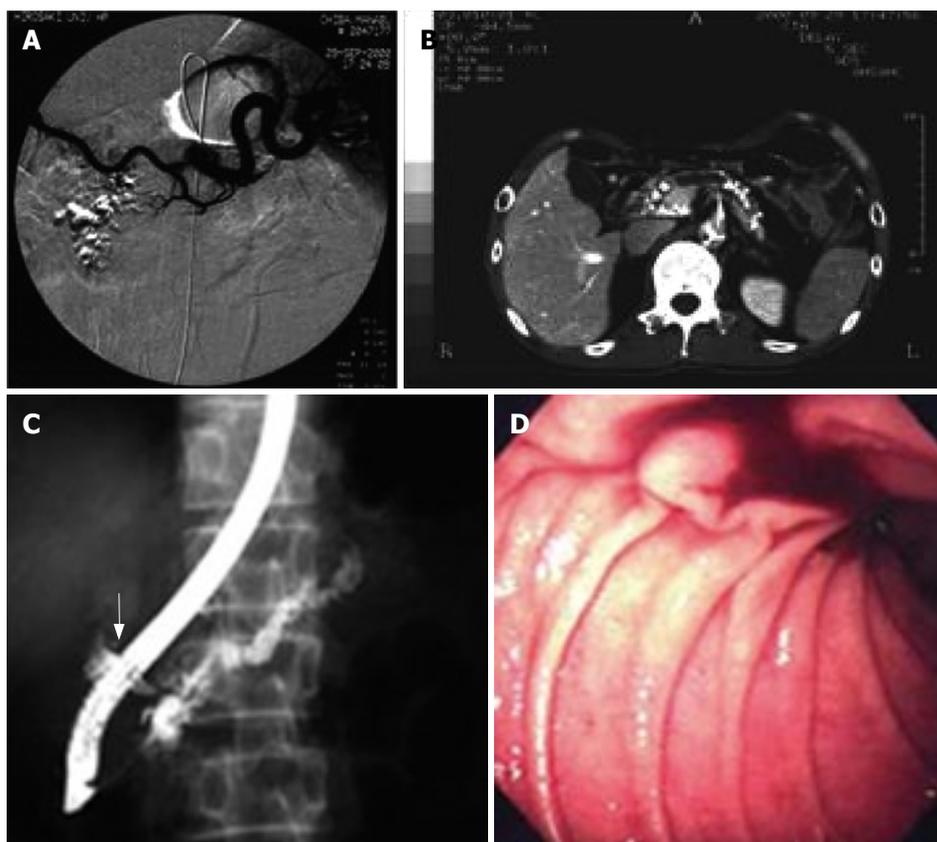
Case 2. Pseudoaneurysm in pancreatic pseudocyst. A: Angiography failed to detect a bleeding point; B: CT scan shows multiple calcifications at the whole pancreas and dilatation of main pancreatic duct; C: Endoscopic retrograde pancreatography displays a dilatated branch of pancreatic duct at head of pancreas (arrow); D: Endoscopy reveals bleeding from papilla of Vater.
